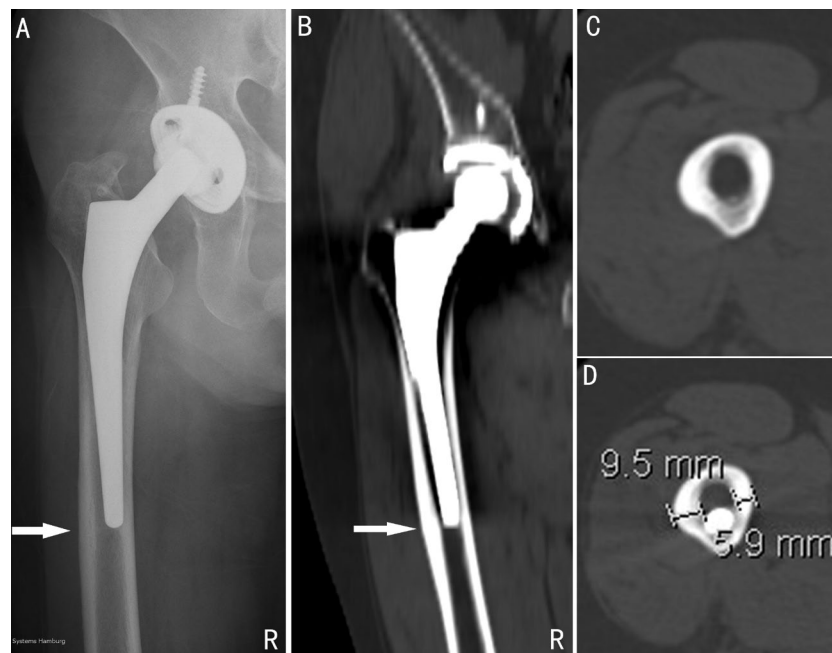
Radiographs (A,B) shows diffuse cortical thickening and beaking on the lateral cortex of the right femoral shaft near the distal hip prosthesis where the stress concentrated (arrow); The coronal cuts of CT scans (C,D) reveals that the size of the lateral cortical bone (9.5 mm) is thicker than the medial one (5.9) obviously at the location where the stress reacts.
